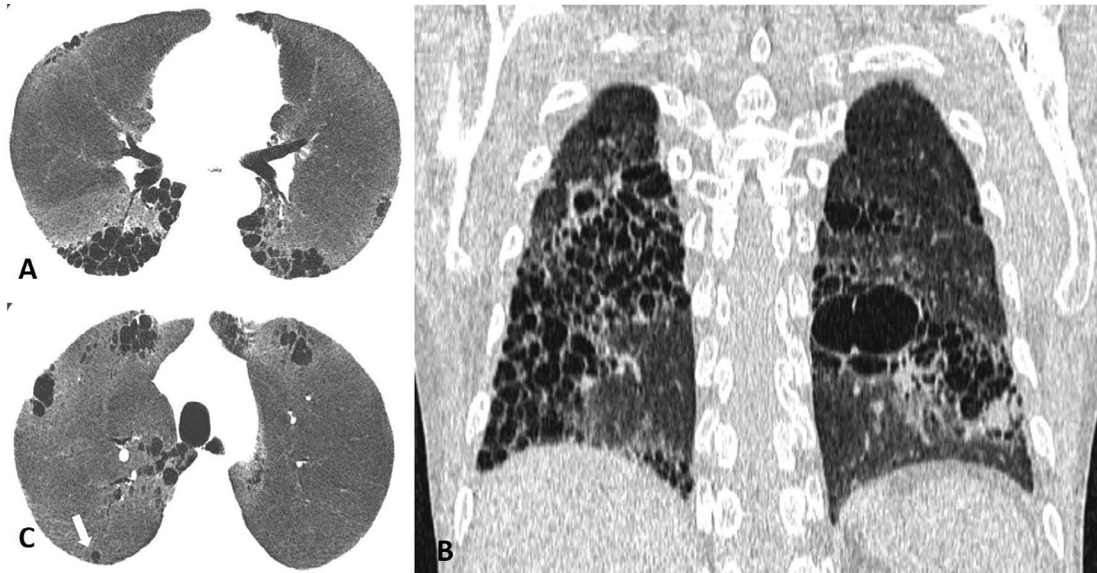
High-resolution computed tomography of the chest. Axial image (A) with minimum intensity projection and coronal reconstruction image (B) showed diffuse reticular opacities, ground-glass opacity, extensive bilateral honeycombing and traction bronchiectasis predominantly in the bilateral subpleural lower lobes of the lung. (C) Note the presence of several simple cysts (arrow)
